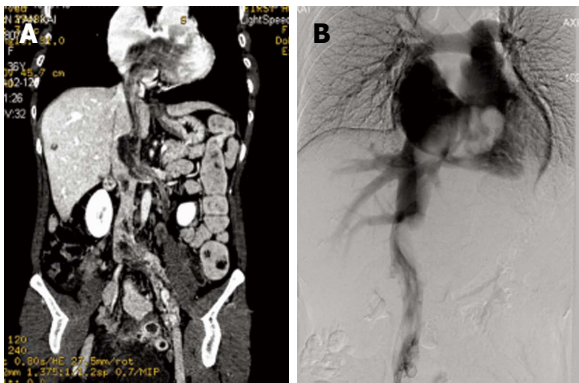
Coronal plane computed tomography and digital subtraction angiography image of intravenous leiomyomatosis. A: Preoperative coronal plane computed tomography demonstrates a mass was present in the left ovarian vein, left renal vein, left external and common iliac vein, as well as within the inferior vena cava, extending into the right atrium; B: Digital subtraction angiography image demonstrates an irregular mass filling defect from the inferior vena cava to the right atrium.
